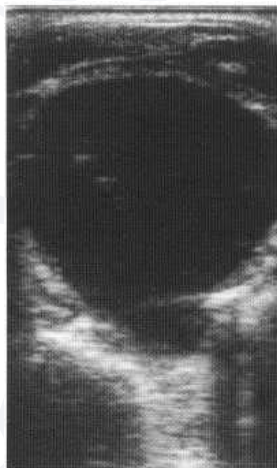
Ultrasound of a large cystic mass within the right lobe of the thyroid demonstrates small focal regions of increased reflectivity with 'comet tails' due to a colloid cyst.
